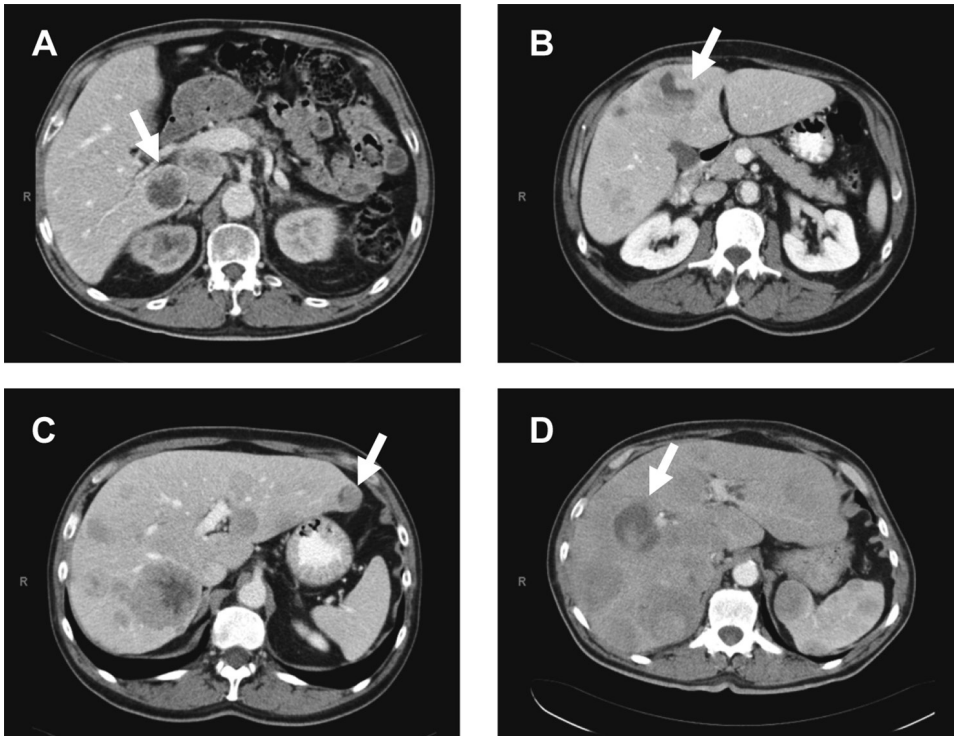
Aspect of heterogeneity on CT (transversal slices) assessed in the venous phase of contrast enhancement of liver metastases in gastroenteropancreatic and bronchial NETs. Arrows indicate relevant liver lesion. (A) Small dense area on side. (B) Hypodense irregularly shaped area in middle. (C) Small hypodense area on side. (D) Dense irregularly shaped area in middle.
